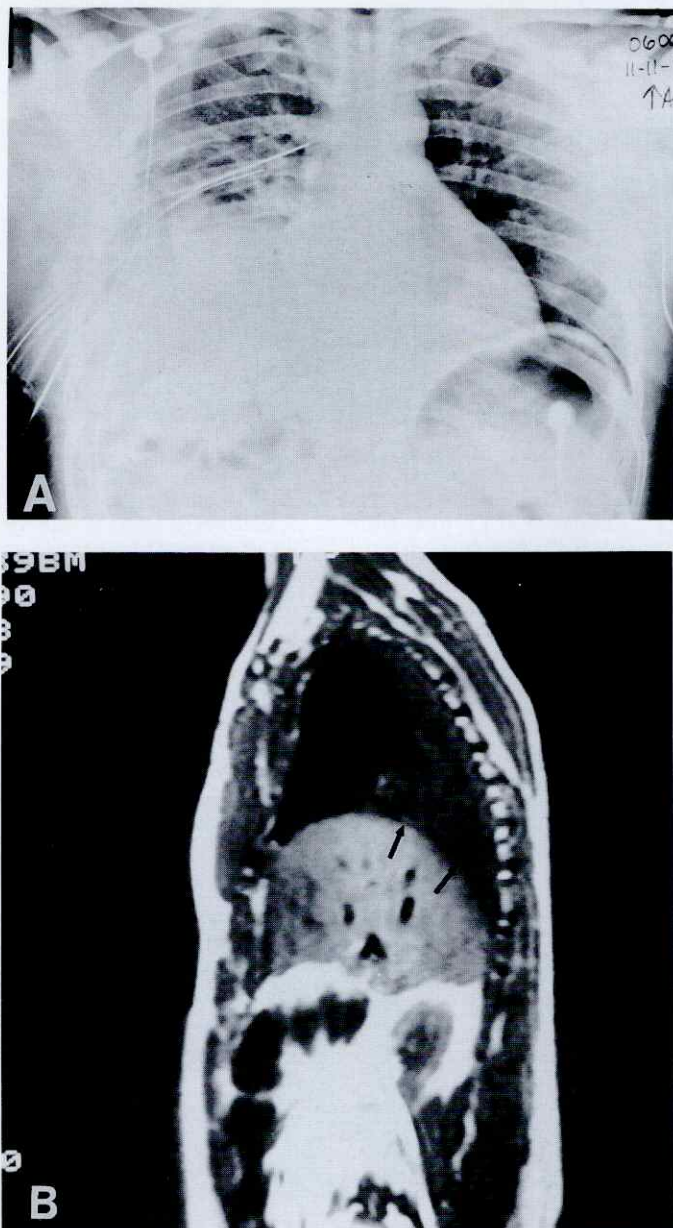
Magnetic resonance images excluding right diaphragmatic rupture: (A) Erect chest x-ray film of a 37-year-old man after blunt chest trauma revealed apparent elevation of the right hemidiaphragm with poor definition of the diaphragm contour. (B) Sagittal MR image, T₁-weighted, shows an intact thin low-signal line representing the right hemidiaphragm (arrows), with right posterior lung atelectasis most likely accounting for diaphragm elevation.
